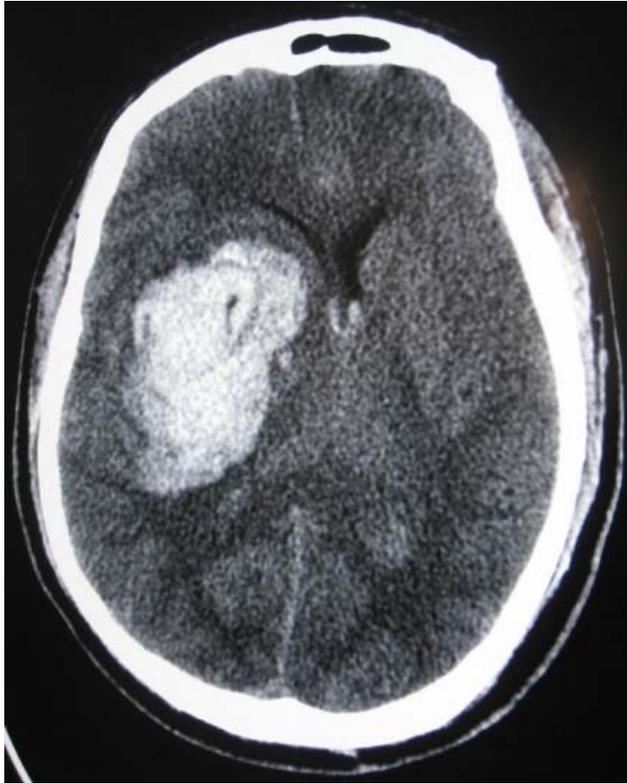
Preoperative CT scan. The intra-cranial hemorrhage in the right side of the basal ganglia.
